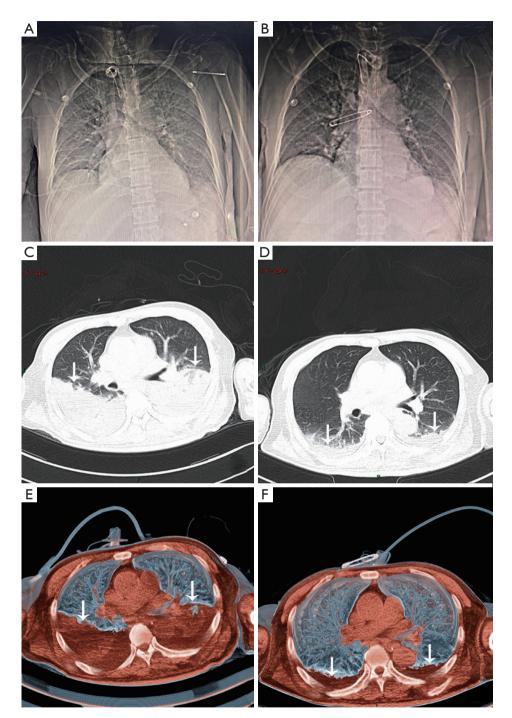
Comparisons of lung CT images before and after recruitment therapy. (A) Bedside chest radiographs before lung recruitment showing decreased lung tissue transmittance and ground-glass changes; (B) bedside chest radiographs 3 days after lung recruitment showing significantly increased lung tissue transmittance and reduced ground-glass changes; (C) CT image before lung recruitment showed partial swelling of the lungs and large dorsal consolidation shadows (arrow); (D) CT image 3 days after lung recruitment showing inflated parts in both lungs and dorsal consolidation contrast. The front is significantly reduced (arrow); (E) 3D reconstruction of chest CT (abdomen and lung structure rendering) before lung recruitment showing partial swelling of the lungs and large dorsal consolidation (arrow); (F) after lung recruitment, 3D chest CT reconstruction (abdomen and lung structure rendering) showing inflated parts of the lungs and reduced consolidation of the dorsal side (arrow).
